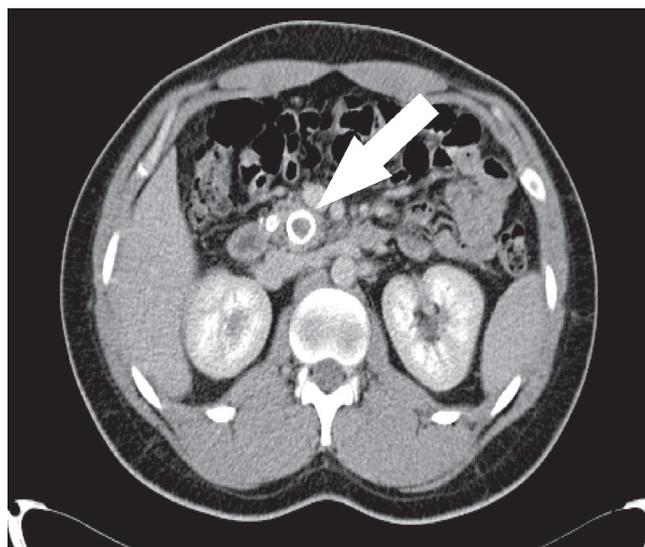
Computed tomography (CT) of the pancreas. The arrow points to a large, calcified structure with a diameter of 22 mm the in distal segment of Wirsung's duct.
